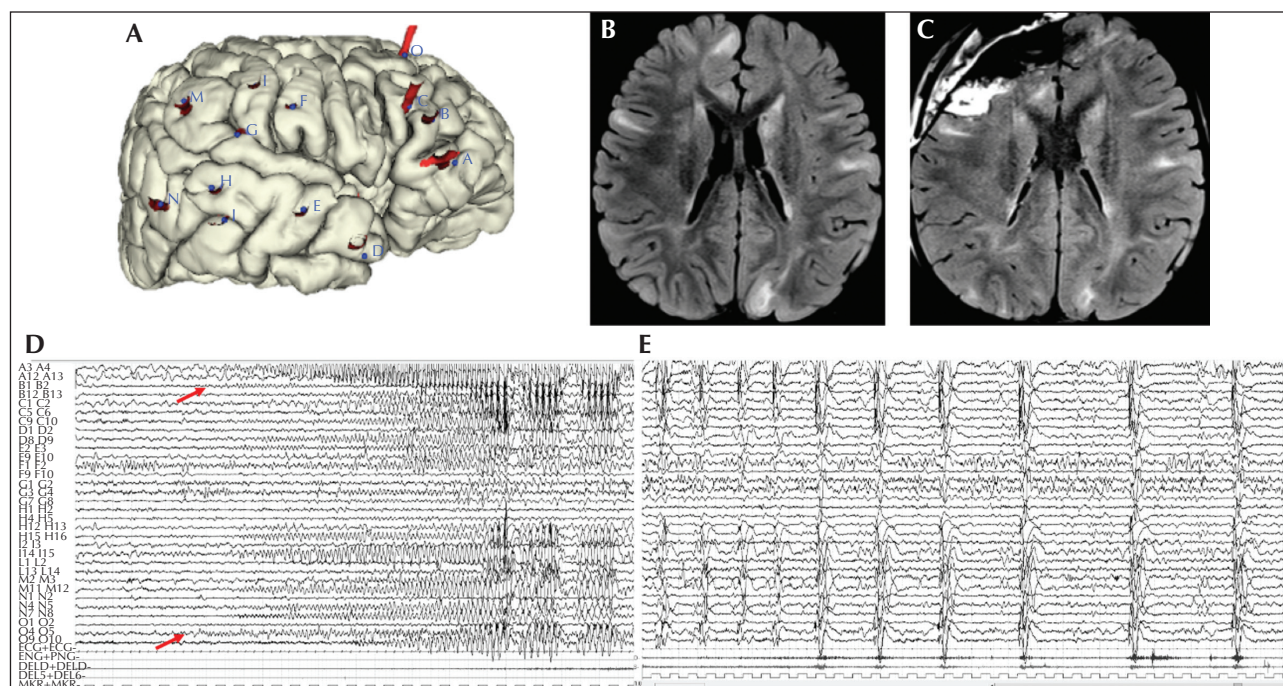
Presurgical evaluation and surgical approach in a five-year-old patient with a *TSC1* genetic variant. Epilepsy onset occurred at four months of age, with epileptic spasms without clear-cut clinical lateralization. Afterwards, the patient started to present with focal seizures characterized by right head deviation and diffuse tonic contraction (left>right), followed by subtle epileptic spasms (mild head deviation). Psychomotor development was moderately delayed, language was strongly delayed, and autistic features were evident. Video-EEG showed right multifocal continuous interictal epileptiform abnormalities. (A) Intracranial SEEG exploration of the right hemisphere using 18 electrodes: four electrodes (A, B, C, O) were used to explore the frontal lobe, both basal and dorsal surface; six electrodes (D, E, H, I, N, G) for the temporal lobe; and three electrodes (F, L, M) for the posterior parietal area. (B) Preoperative brain MRI showing multiple bilateral tubers with hyperintensity on FLAIR-weighted sequences. (C) Post-operative brain MRI showing that the resection area corresponded to the right fronto-basal region which was identified by the SEEG study. Three years post-surgery, the patient was seizure-free, with improvement in language and interaction. (D) The SEEG recording showing a focal seizure starting with a low-voltage fast discharge over electrodes B, C, O, followed by rhythmic theta activity at the same electrodes and over electrode A; soon after, the ictal discharge involved temporal electrodes (D, E, H, M, N) with spike and spike-and-wave complexes. (E) The focal seizure was followed by a cluster of epileptic spasms characterized by pseudorhythmic complexes of spikes, followed by a high-voltage slow wave, mixed with fast activity evident at electrodes A3-4. The clinical counterpart was subtle (mild bilateral muscular activation on polygraphic traces).
